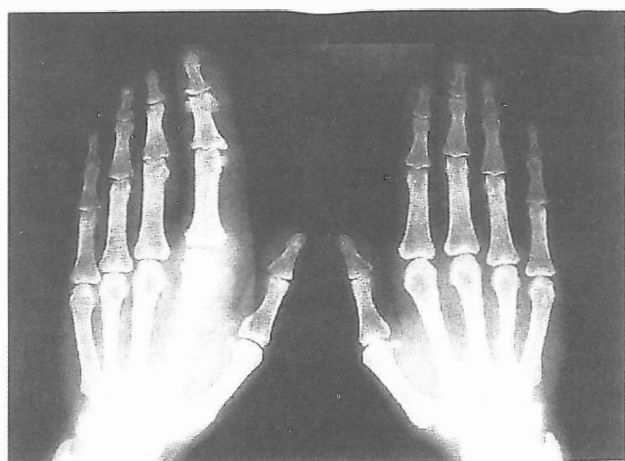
This is the radiograph of the patient's hands 10 years ago. In comparison with Fig. 1b progression is obvious.
